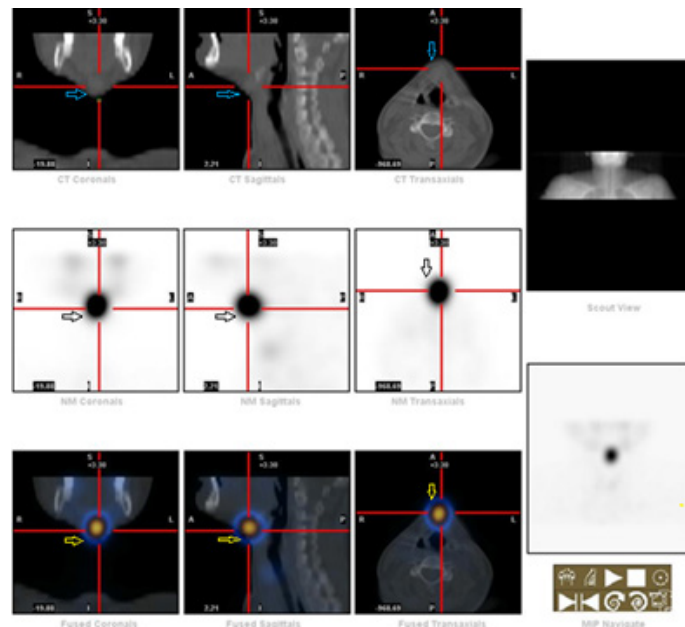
SPECT-CT images of ^{99m}Tc-pertechnetate scan. The scan localized distinct pertechnetate-avid focus (black arrows) as soft tissues density lesion (blue arrows) measuring 1.6 × 1.7 cm at the submental region.
